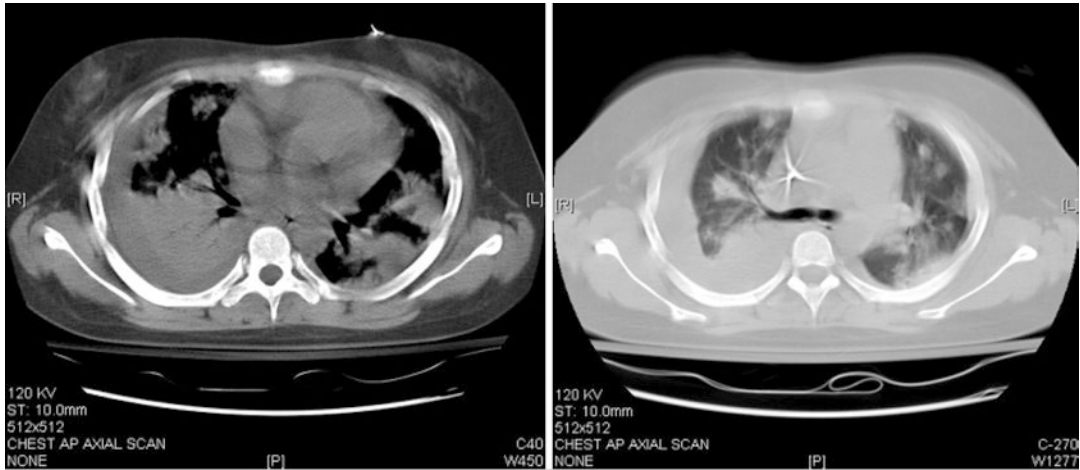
A chest computed tomography demonstrated septic emboli of both lung fields and right side pleural effusion/empyema
